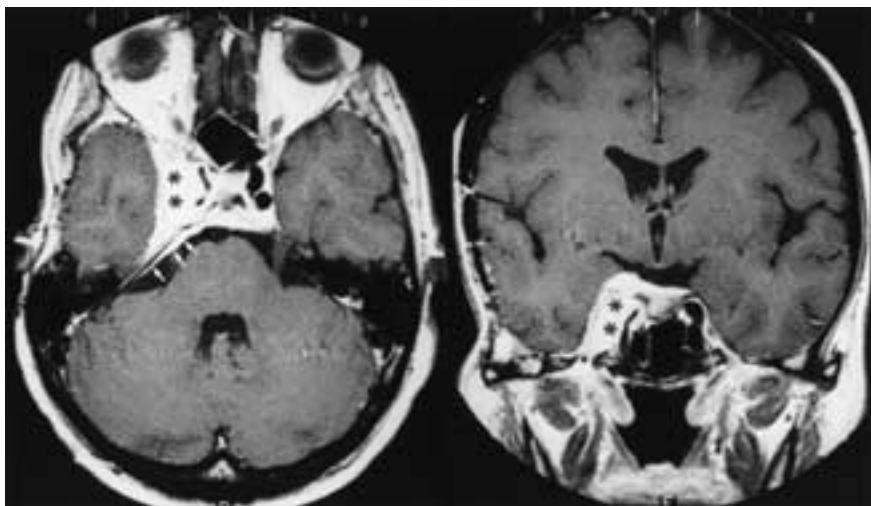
Cavernous sinus/Meckel's cave meningioma with extension through the foramen ovale. Left (axial) and right (coronal) contrast-enhanced T1-weighted MR images without fat suppression show a characteristic right cavernous sinus/Meckel's cave meningioma (*asterisks*). Note the dural tail extending posteriorly along the right petrous ridge (*arrows*). The lesion is seen on the coronal image to be extending inferiorly through a widened foramen ovale (*black dot*). (From Ginsberg LE. Imaging of perineural tumor spread in head and neck cancer. *Semin Ultrasound CT MR* 1999;2:175–186.)
